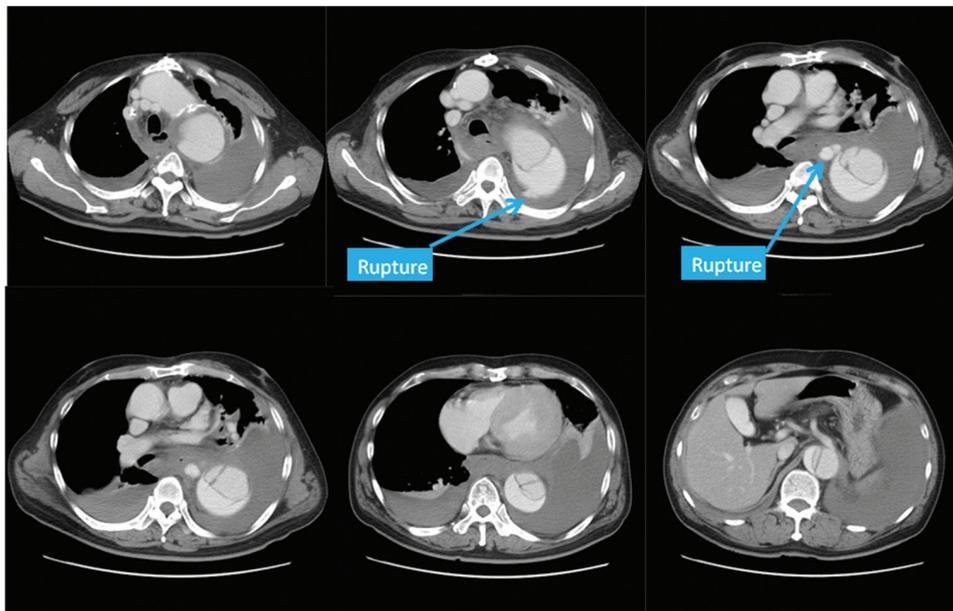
Computed tomography scan demonstrates rupture of three-channeled acute aortic dissection on fourth hospital day. Contrast media is leaking out of the aortic wall.
